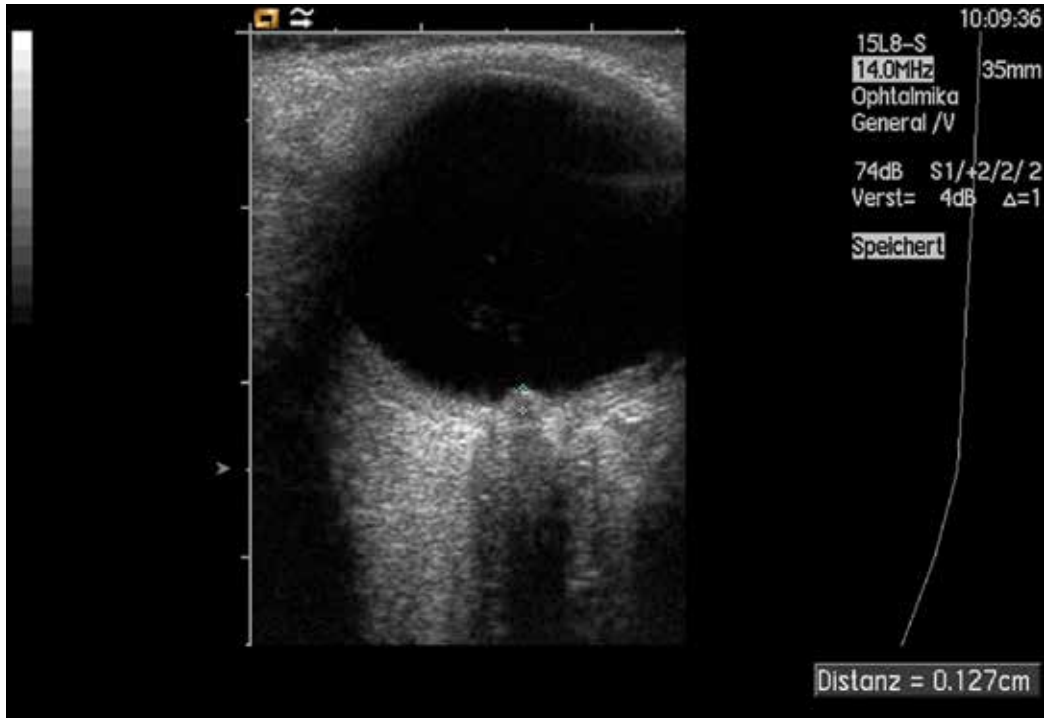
Measurement of papilledema using ultrasound: disc elevation is quantified by putting the first caliper on the uppermost part of the swollen disc, the second caliper is positioned on the strongly reflecting line representing the lamina cribrosa
